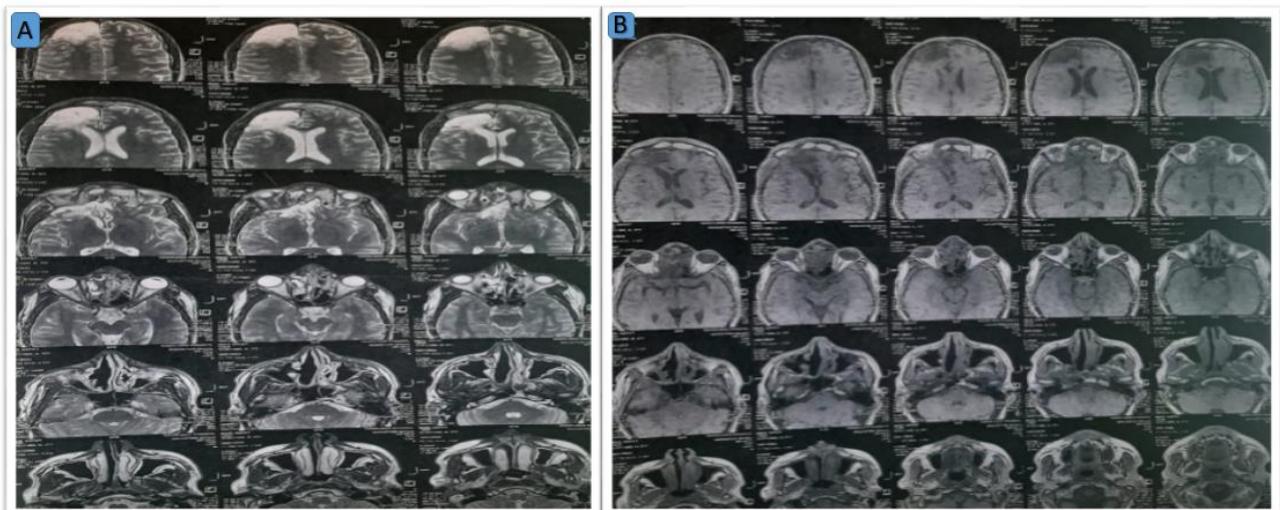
Craniocervical MRI post chemotherapy; A) T2 sequence, B) T1 sequence
